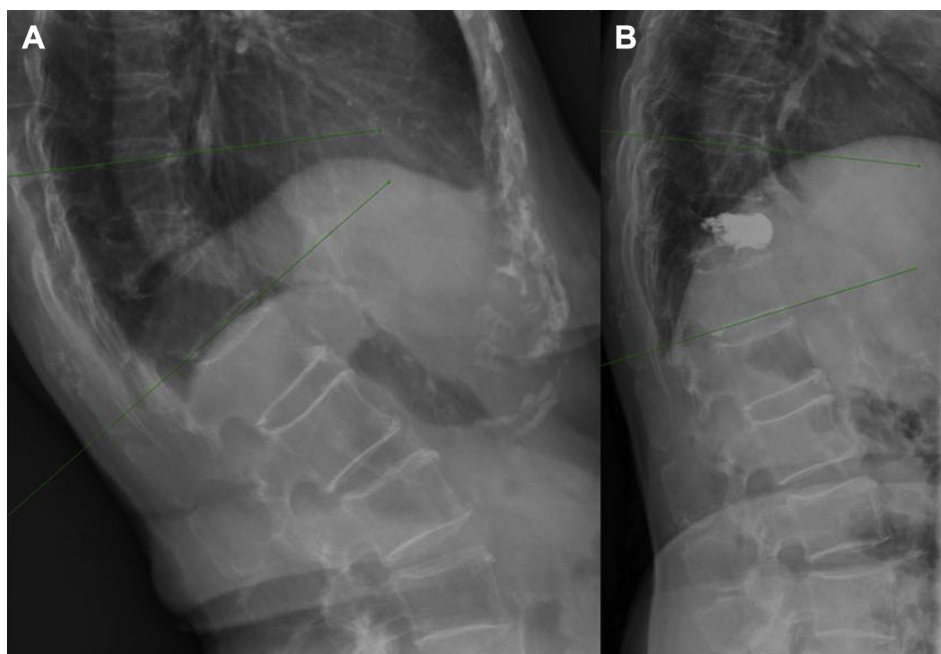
Anteroposterior and lateral plain films of an 83-year-old woman with a T11 compression fracture who had suffered from intermittent low-back pain for 2 months. (A) Initially, the anterior column of the vertebrae was severely collapsed. The compression ratio was 31.4% and the kyphosis angle was 29.2°. (B) With a postural reduction and subsequent vertebroplasty, the collapsed vertebra was re-expanded and consolidated. The compressed vertebra was restored to 73.2% of its original height, and kyphosis was corrected to 14.5°.
